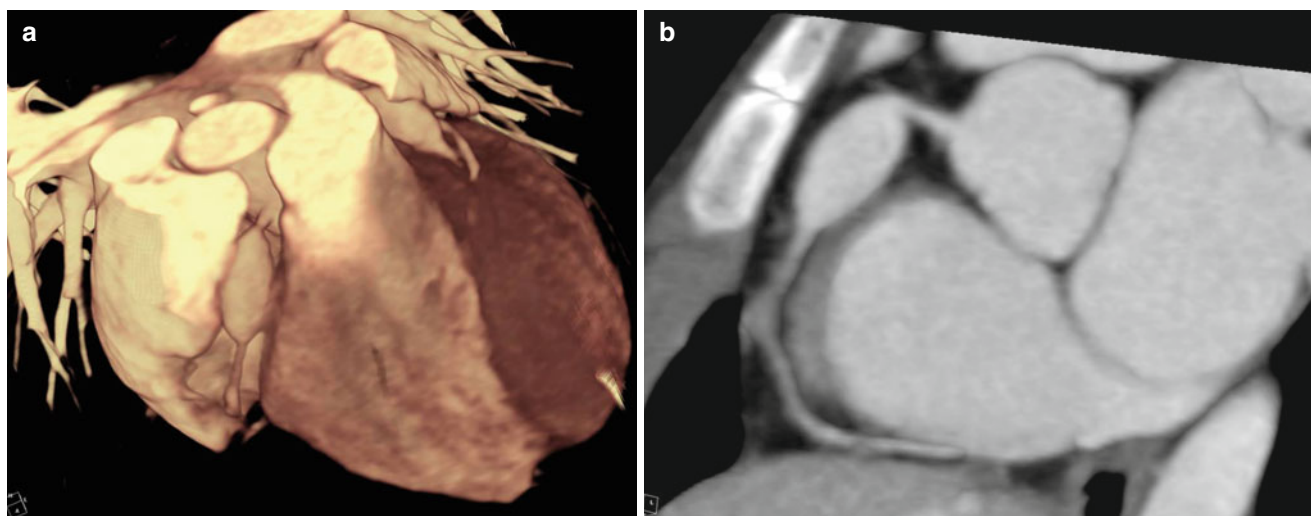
A 6-year-old girl with Kawasaki disease presenting with non-thrombosed coronary aneurysm. (a) 3D volume-rendering CT image shows fusiform aneurysm at the right coronary artery and the left
